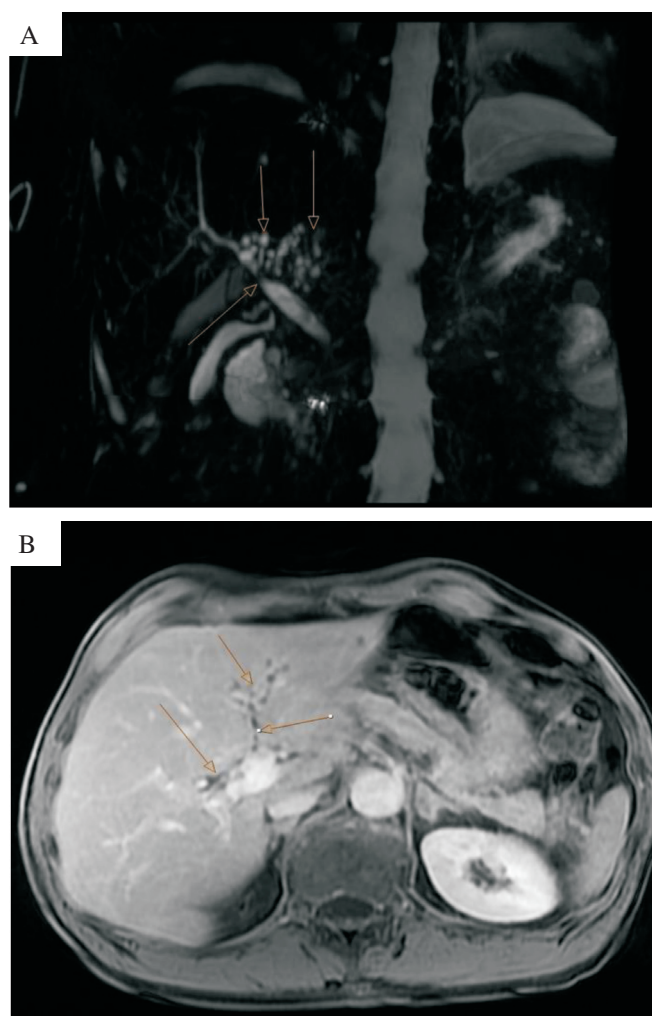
Abdominal magnetic resonance imaging. Segmentally dilated ductus hepaticus communis (A); dilated intrahepatic bile ducts (B).
